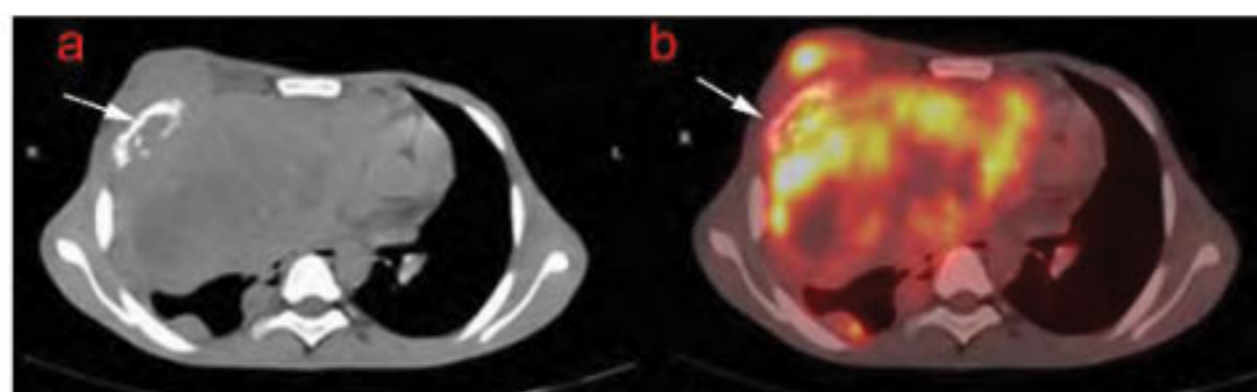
Transaxial ^{18}F -FDG images: (a) CT (b) PET/CT showing involvement of the right 4th rib with a lytic lesion (arrow). Areas of necrosis are also noticed in the mass on CT images with photopenic areas on PET/CT, suggestive of necrosis.
